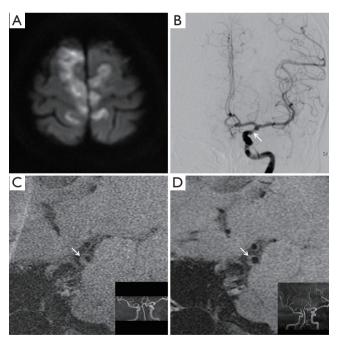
Diffusion weighted imaging (A) and angiography (B) showed ischemic infarcts due to left internal carotid artery stenosis with an azygous anterior cerebral artery. On T1-weighted images of high-resolution MRI, a plaque (arrow, C) was identified, which was retracted (arrow, D; maximum plaque area from 0.15 to 0.10 cm²) after treatments.
